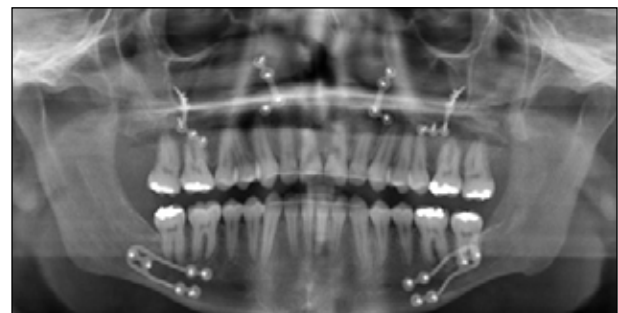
Panoramic radiograph after orthognathic surgery.
